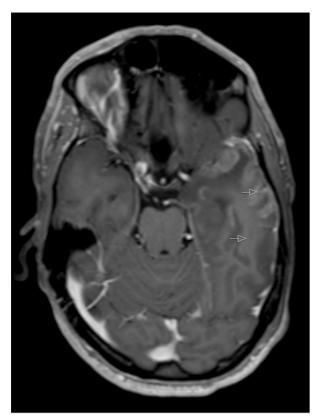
First axial contrast-enhanced T1-weighted MRI, showing hyperintense signal areas diffusely in the white matter in the left temporal lobe, with cortical contrast enhancement along the lateral and anterior-medial-basal parts of the left temporal lobe (arrows). Similar but less prominent changes are seen in the right temporal lobe. The interruption of the anatomical continuity of the lateral aspect of the right temporal lobe is an artifact.
